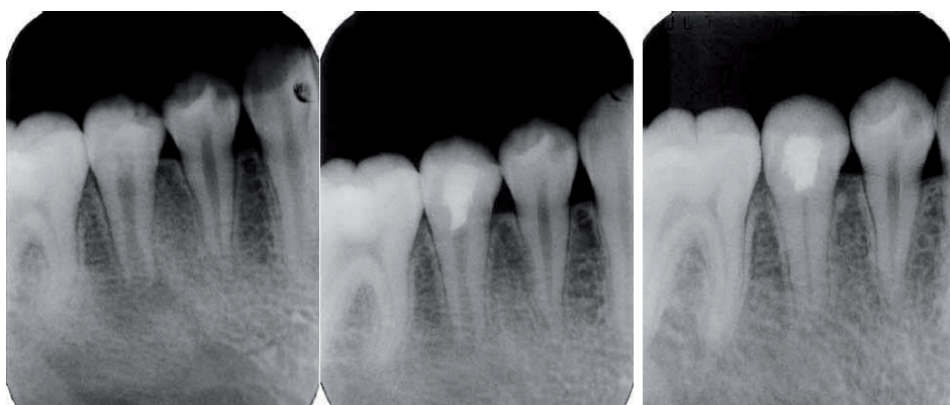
On the left side, pre-operative radiograph of lower right 2nd premolar with open apex, incomplete root formation and periapical radiolucency. In the middle, radiograph taken after five months of calcium hydroxide dressing. On the right side, 35 months after treatment completion revealing complete root formation increase in root width and length [8].
